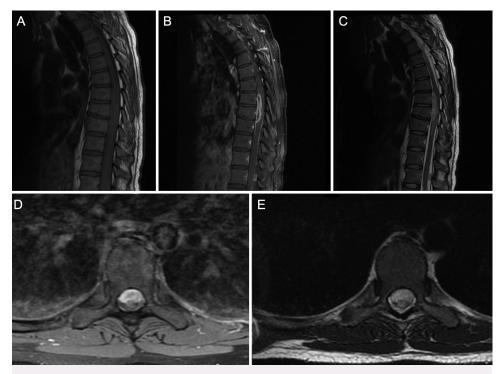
Case 1. Sagittal T1-weighted (A), T1-weighted postcontrast with fat saturation (B), and T2-weighted (C) MRI demonstrating T1 isointensity, T2 hyperintensity, and enhancement of the mass spanning two vertebral body levels and filling the canal. Heterogeneous enhancement could represent areas of necrosis. There is a T2-hyperintense signal abnormality of the adjacent cord. Axial T1-weighted postcontrast with fat saturation (D) and T2-weighted (E) MRI demonstrating the mass filling the canal and resulting cord compression. There is a focal area without a clear plane between the cord and mass with associated cord signal abnormality suspicious for infiltration.
